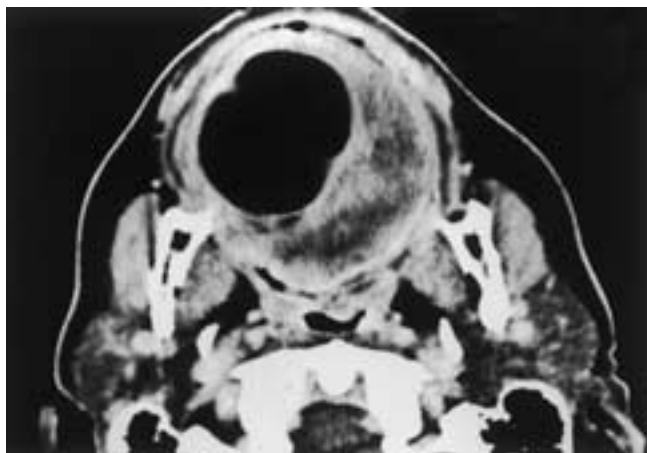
Lipoma. Axial contrast-enhanced CT scan demonstrates a very hypodense lesion compatible with fat in the tongue that is virtually indistinguishable from subcutaneous fat.
